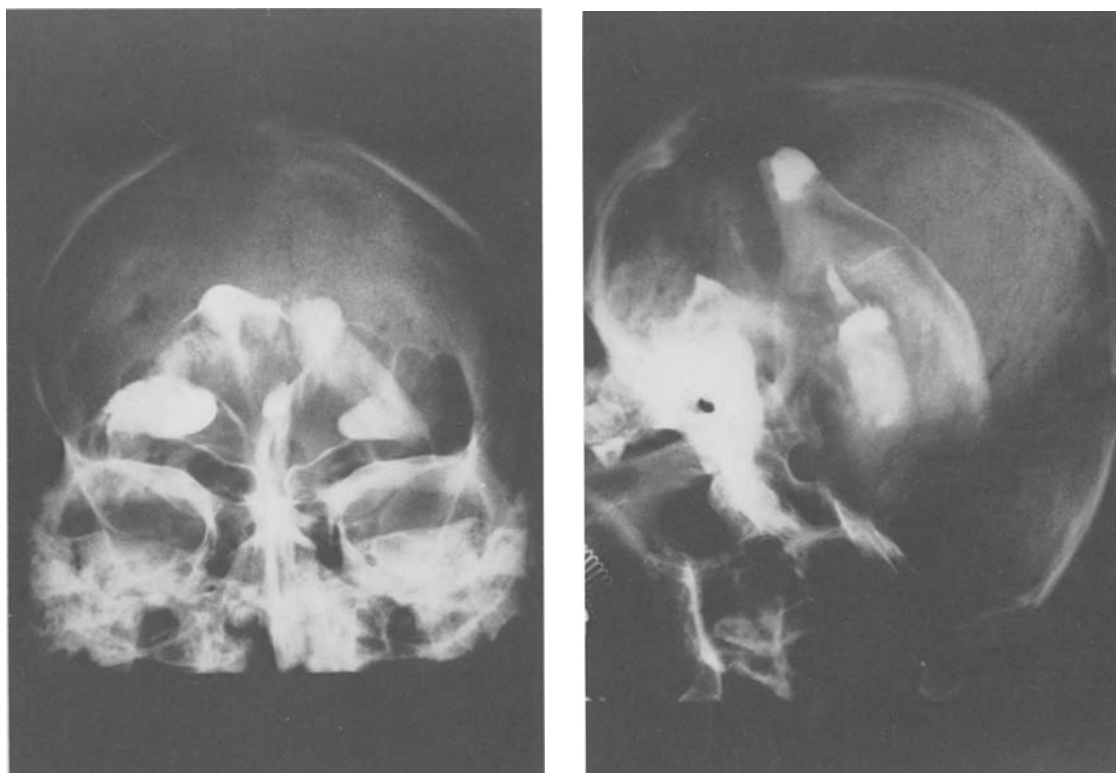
(a+b). Plain film ten minutes after injection of contrast medium: Complete ventriculogram visible. Contrast medium within the haematoma still apparent.
